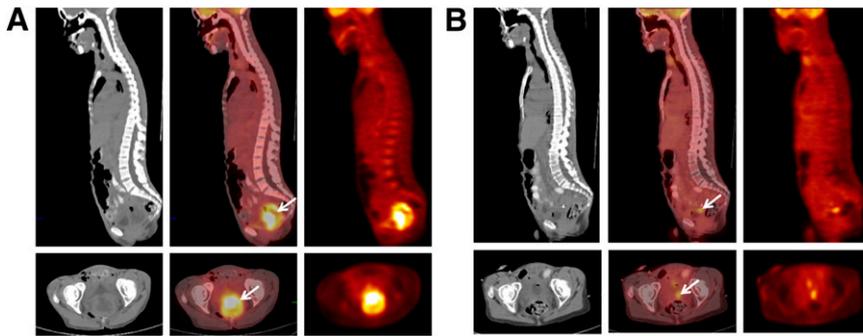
^{18}F -FDG PET of partial metabolic response in 54-y-old woman with newly diagnosed International Federation of Gynecology and Obstetrics stage III squamous cell carcinoma of cervix. (A) At initial staging, sagittal (top) and transaxial (bottom) CT (left), fused PET/CT (middle), and PET (right) demonstrate intense ^{18}F -FDG uptake (SUV, 15.3) within large cervical mass. (B) Three months later, after concurrent radiochemotherapy, sagittal (top) and transaxial (bottom) CT (left), fused PET/CT (middle), and PET (right) show that ^{18}F -FDG uptake has improved but remains focally increased (SUV, 5.4) within residual cervical mass, consistent with partial metabolic response.
